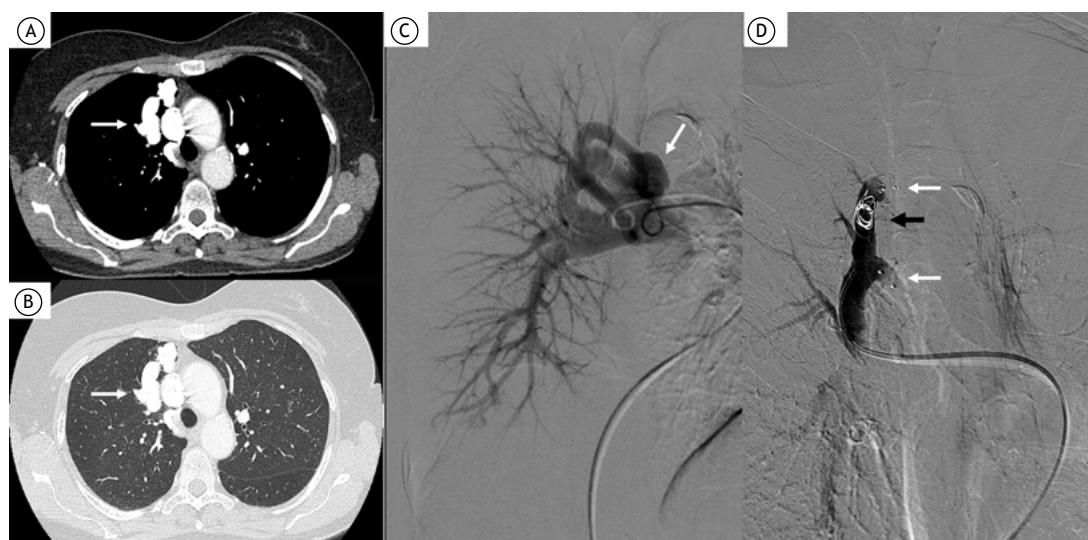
Combined coils and Amplatzer embolization. In A and B, respectively, CT scans of the chest with mediastinal and lung window settings showing the pulmonary malformation (white arrows). In C, localization of the malformation by pulmonary angiography (white arrow). In D, embolization with coils (black arrow) and Amplatzer vascular plug (white arrow).
